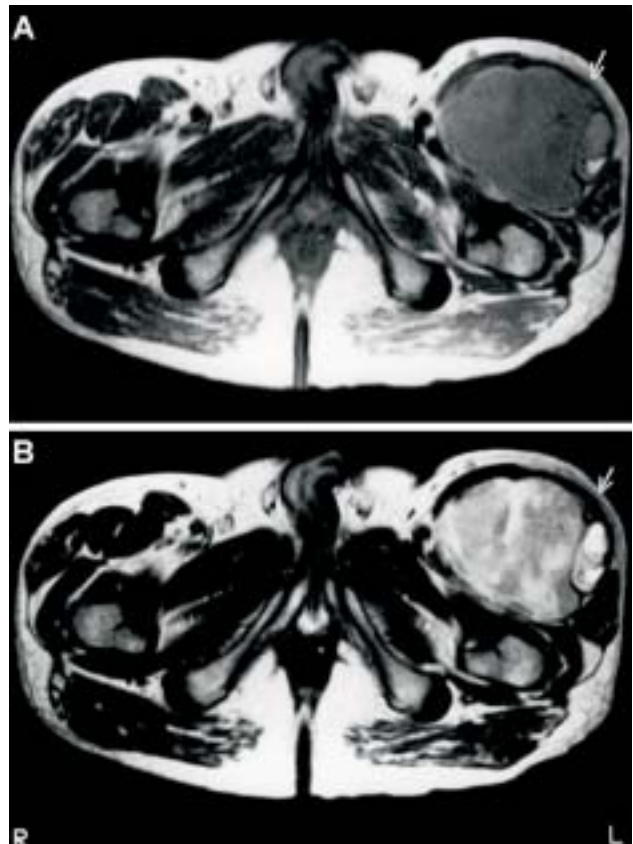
Malignant fibrous histiocytoma of the left upper thigh in a 63-year-old male. (A) Axial T1-weighted (1321/13/2) spin-echo image shows mild inhomogeneity (arrow). (B) Axial T2-weighted (2998/110/4) spin-echo image shows complex homogeneity (arrow).
